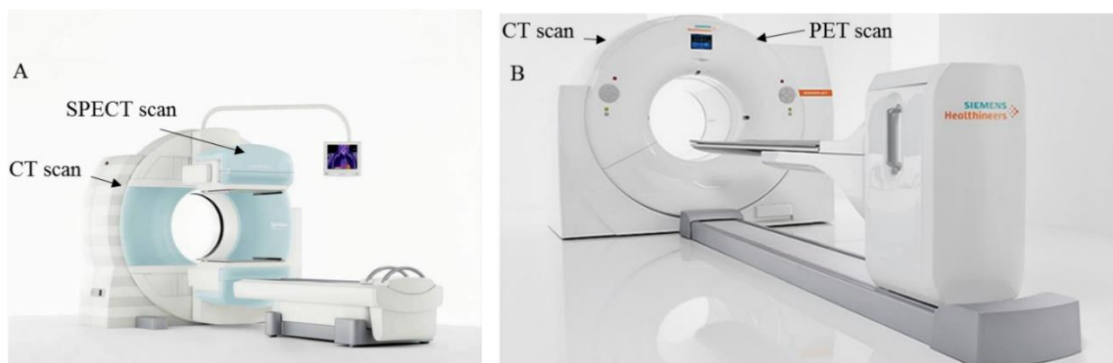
Siemens Medical Solutions USA. SPECT/CT Symbia T Series (A), reproduce with permission [71], and PET/CT Biograph Vision (B), reproduced with permission [72].
